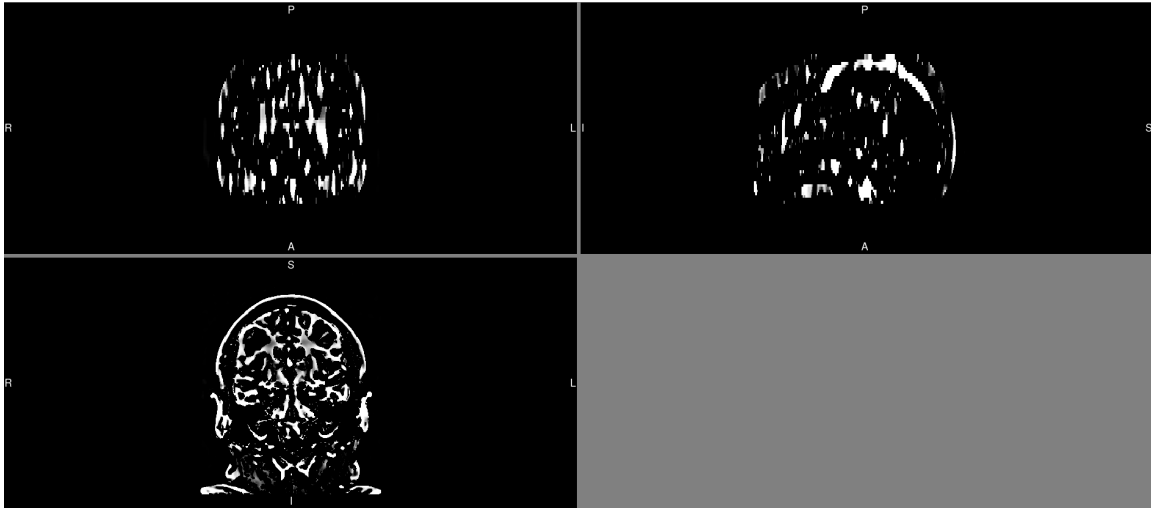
Vesselness maps with the following characteristics: $\alpha=0.05$, $\beta=20$, $c=30$. For the scanner on which most of the pre and post contrast MRI pairs have been acquired, these are the values which have been shown to be most useful in generating reliable SSS extraction maps.
